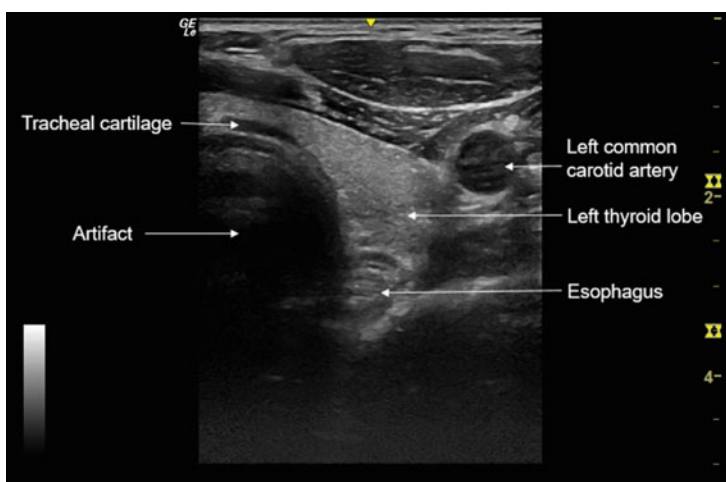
A cross sectional ultrasound image of the neck showing a normal appearing esophagus. Note the esophagus is seen deep to the left lobe of the thyroid gland
